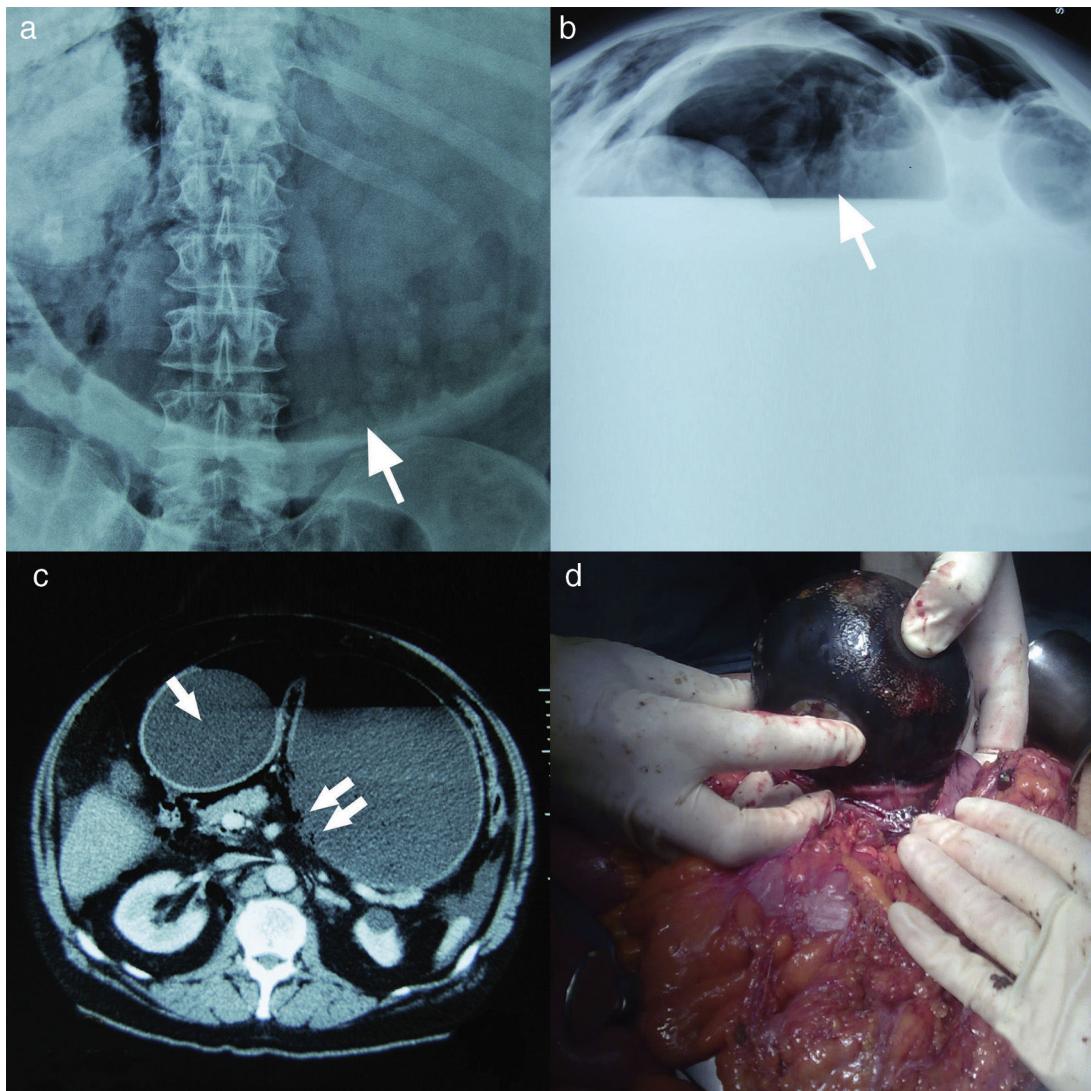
(a and b) Plain X-ray of the abdomen, anteroposterior view (a) and in decubitus with horizontal beam (b): the massive gastric dilatation is observed (arrow); (c) computed tomography (CT scan): note balloon in antral region (arrow) and massive gastric dilatation with perforation in the posterior wall (double arrow); (d) extraction of the intragastric balloon.
